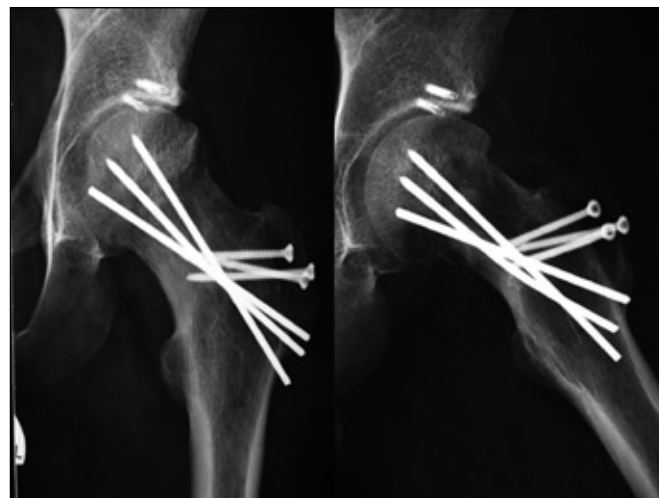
Antero-posterior and lateral X-rays result of subcapital re-orientation, 16 months after surgery (case no. 4). Intraoperatively severe acetabular cartilage damage and labrum disconnection were found and treated with debridement and labrum refixation (two bone anchors). Narrowing of the supero-lateral joint space still present.
